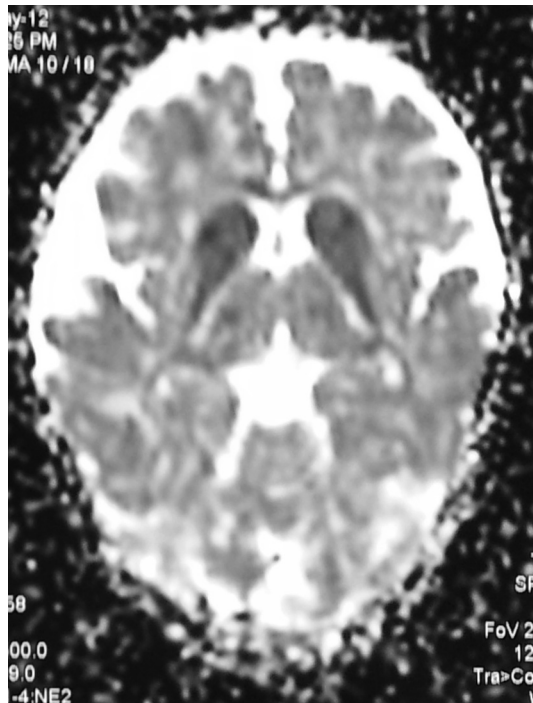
Apparent diffusion coefficient MR imaging showing bilateral symmetric dark signals in the corresponding basal ganglia regions.
